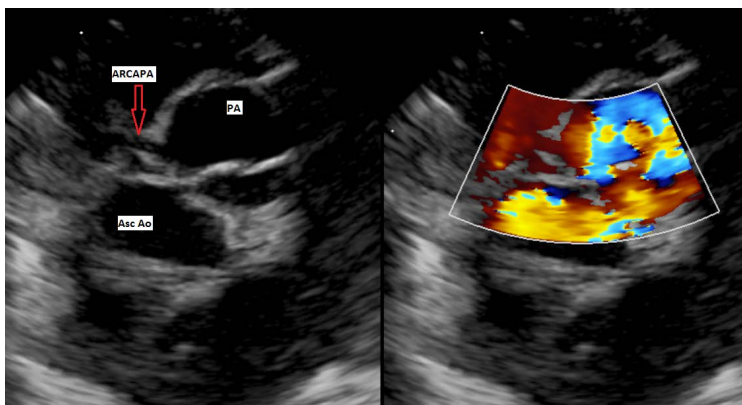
Parasternal short axis view showing anomalous origin of right coronary artery from facing sinus of pulmonary artery (ARCAPA = Anomalous right coronary artery from pulmonary artery; PA = Pulmonary artery; Asc Ao = Ascending aorta)
